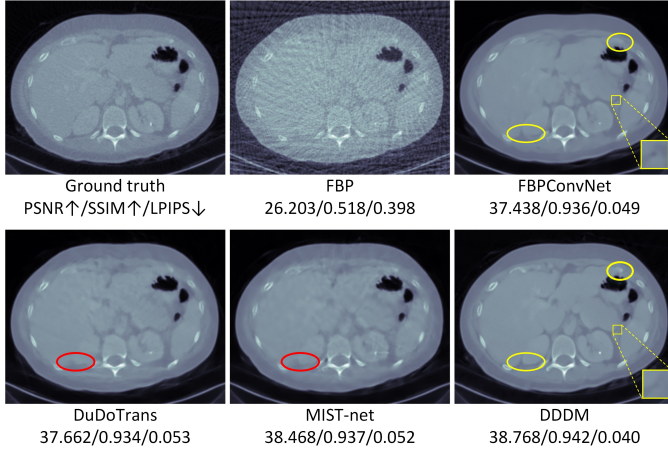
Reconstructed CT images for an abdomen test sample.
